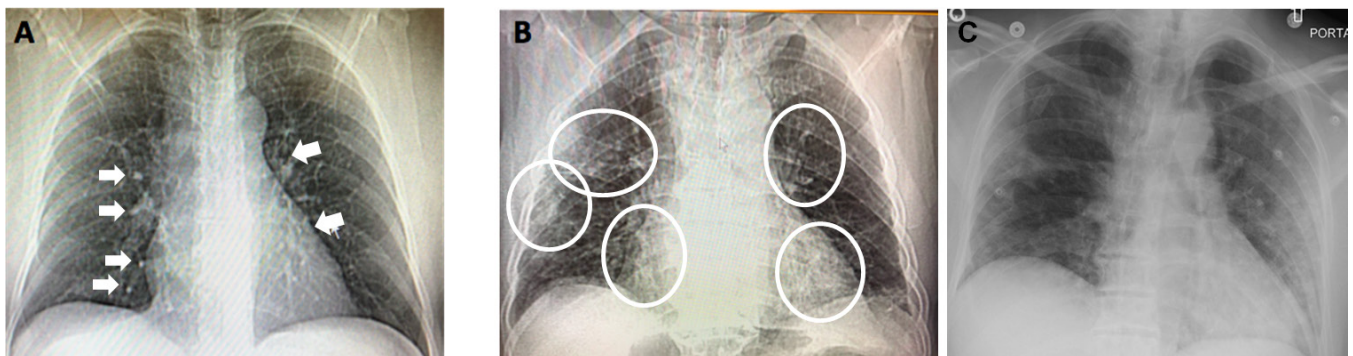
A, Chest CT scan of patient 50M (May 6, 2020) showed mild multifocal ground glass opacity (white arrows) seen in right and left upper lobes and posterior right lower lobe; Inference: most likely representing multifocal pneumonia. B, Chest CT scan of patient 85M (May 8, 2020) revealed heterogeneous ground glass density seen throughout the lungs (circled), with right greater than left. Inference: Moderate multifocal pneumonia with moderate to severe involvement of lower lobes. Findings consistent with known viral (COVID) pneumonia. C, Chest CT scan of patient 80F (May 8, 2020) showing no remarkable abnormalities. Inference: Normal, healthy lungs.
